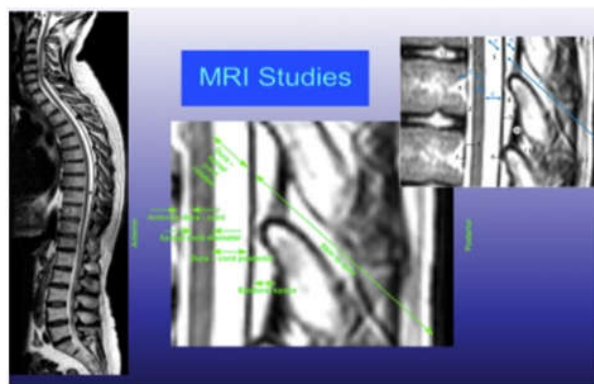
MRI showing increased distance required to reach at spinal cord and dura at mid thoracic levels.
